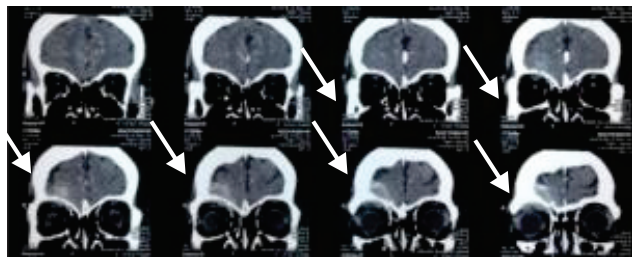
Multi slice head CT scan showed solid extra-axial heterogenic mass in right frontal
